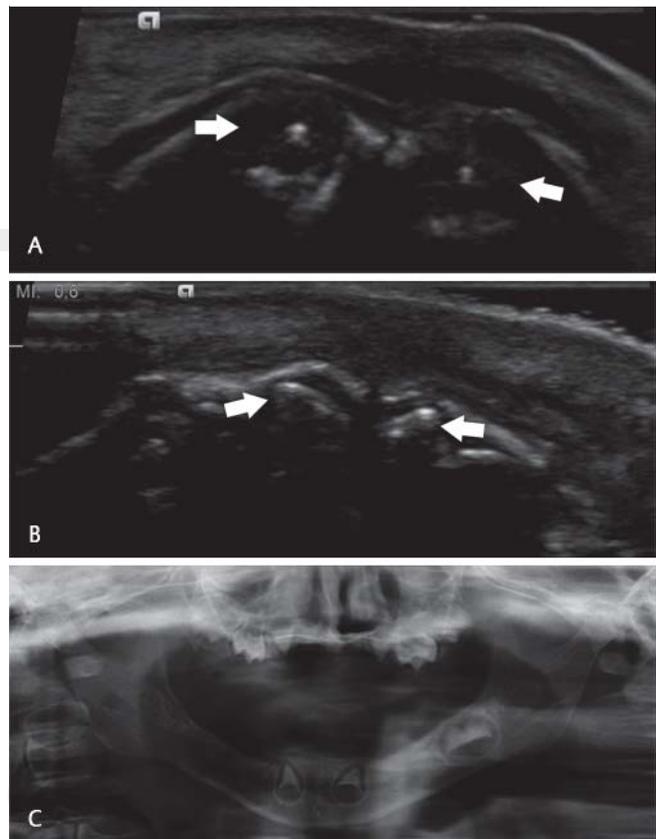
Postnatal confirmation of tooth germ estimates by neonatal sonography or later X-ray examination. A neonatal sonography of the upper jaw of subject M7 with XLHED showing only two round hypoechoic tooth germs (arrowed) with nearly unmineralized pointed teeth; B neonatal sonography of the upper jaw of a healthy control subject with normal tooth germs characterized by hyperechoic, normally shaped teeth (arrowed) and small hypoechoic margins; C dental panoramic radiograph of subject M6 with XLHED at an age of two years allowing reliable tooth quantification and demonstrating oligodontia.
